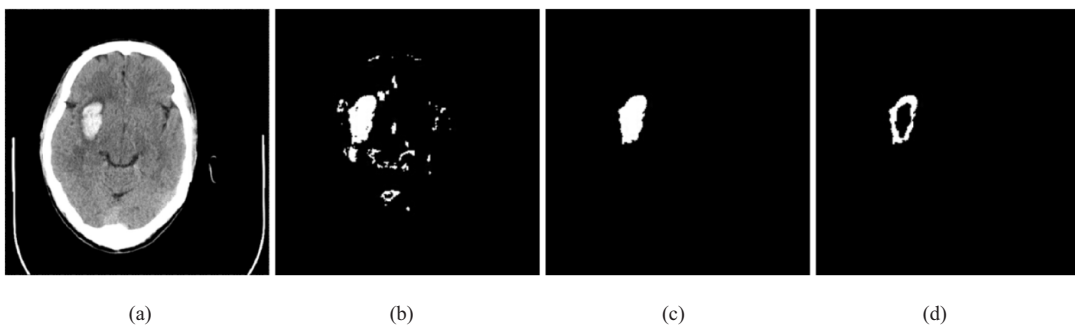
The procedure to segment the edema: (a) the original CT image; (b) foreground derived from the classifier; (c) the lesion after elimination of false foreground and filling holes, and (d) the segmented edema after hematoma is subtracted from the lesion
